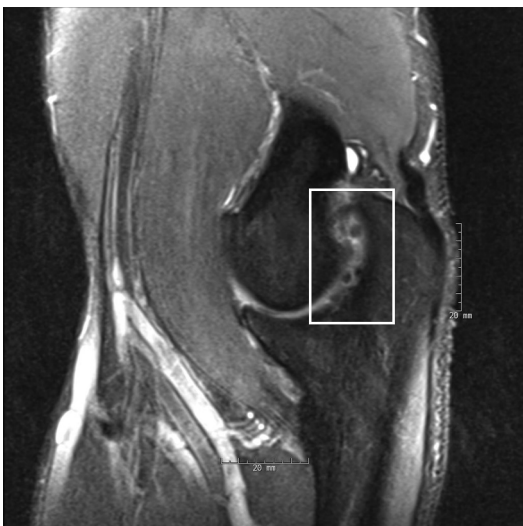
Sagittal cut of an MRI of an overhead throwing athlete demonstrating multiple irregularities of the posterior articular surface of the olecranon (square).
